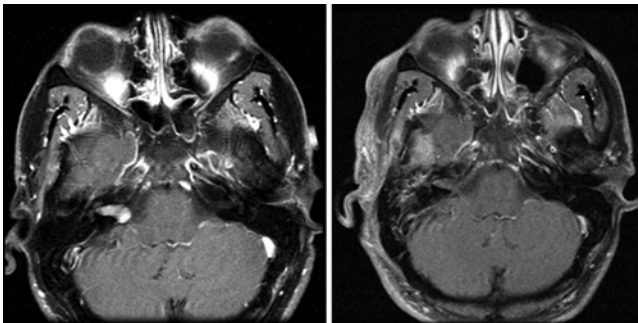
Preoperative (left) and postoperative (right) axial postcontrast T1-weighted MR images revealing complete resection of a right-sided VS via the middle fossa approach.
